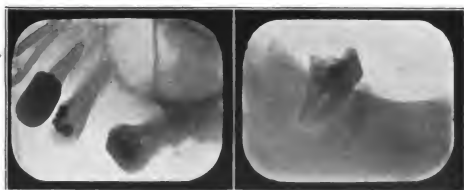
Pathological conditions of the teeth. Radiographs of teeth and roots which had to be extracted on account of chronic abscesses and failure of root canal treatment.
